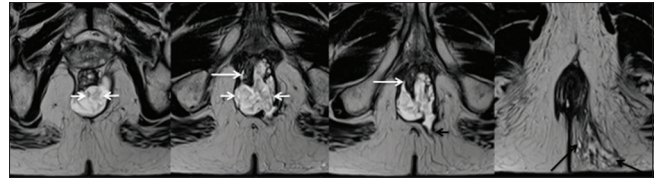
T2-weighted magnetic resonance imaging images showing complex perianal fistula with intrinsic frond-like polypoid enhancing mass. Black long arrows indicate multiple external openings, black short arrow showing one of the tracts, short white arrows showing mass, and long white arrow showing an internal opening in between internal and external sphincter
